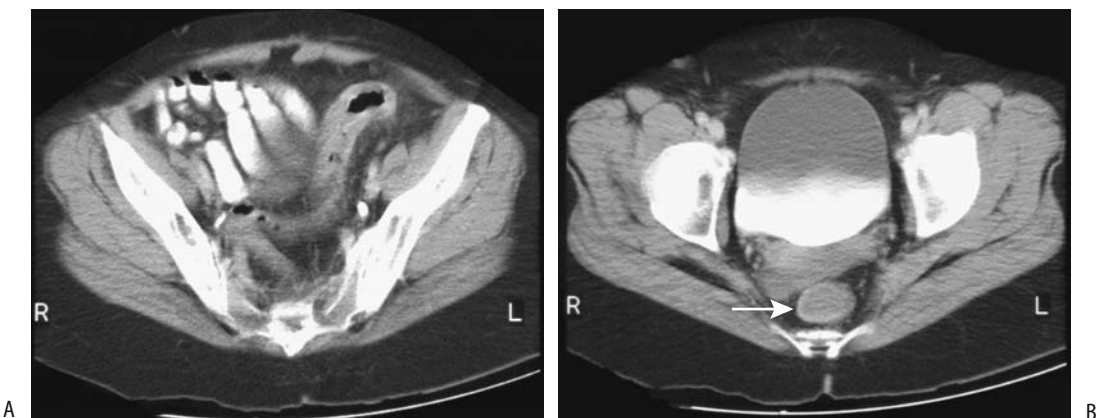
Chemical-induced colitis in a patient who was giving herself hydrogen peroxide enemas for constipation. A,B: CT shows marked rectosigmoid wall thickening (arrows). (Courtesy of Thomas Miller, M.D., San Luis Obispo, California.)
